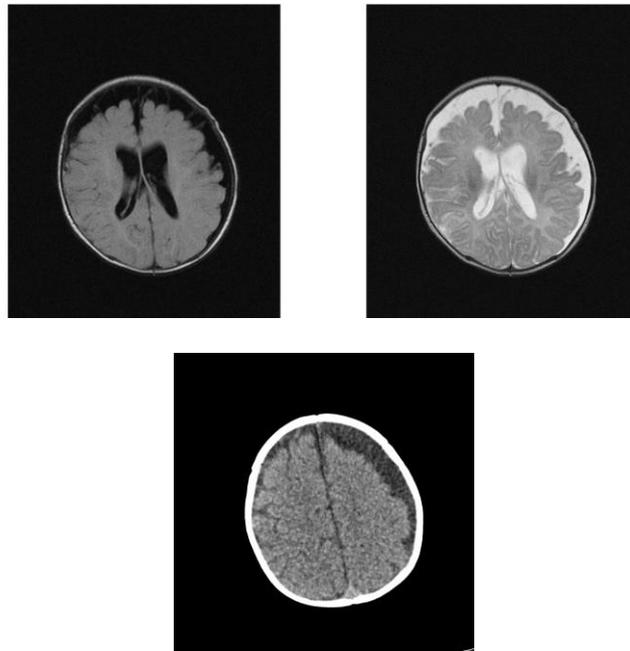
MRI images showing subdural effusions.
